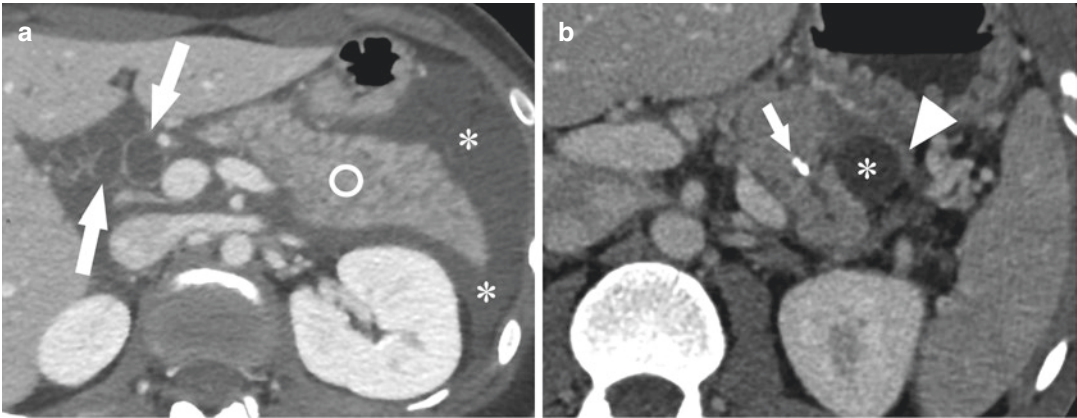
APFC and pseudocyst. (a) IEP with APFC in a 33-year-old woman. Axial contrast enhanced CT image shows homogeneous nonencapsulated fluid collection in the peripancreatic and bilateral anterior pararenal spaces (*); these findings are consistent with APFC. Note diffusely enlarged pancreas with slightly inhomogeneous parenchymal enhancement but no evidence of necrotic areas (circle).
